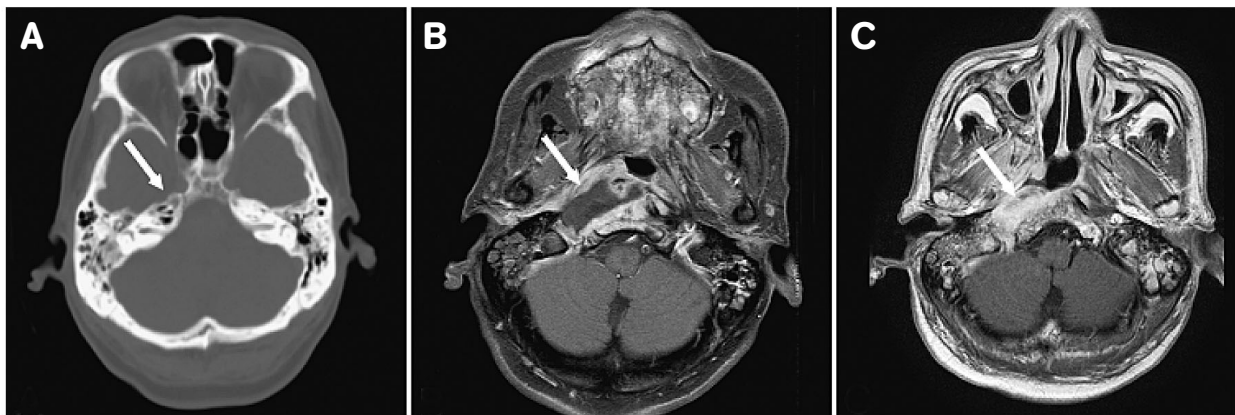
The CT scan with bone window shows an extensive osteolytic lesion in the skull base (A). The MRI shows an abscess adjacent to the clivus and right jugular foramen (B), which resolved 2 months after treatment (C).
